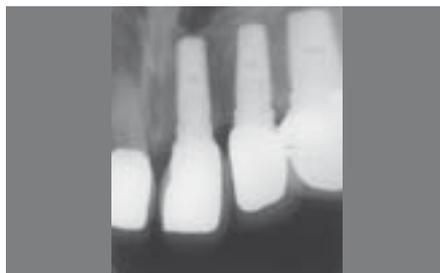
Dental x-ray to assess bone height.
